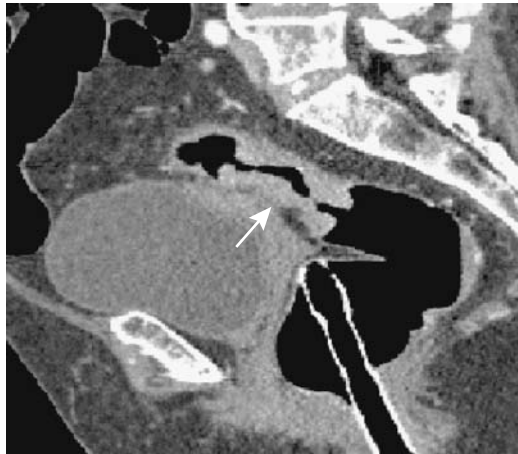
Obstructing carcinoma (arrow). CT colonography can also study the proximal colon. Sagittal images are helpful in surgical planning. (Courtesy of W. Luboldt, M.D., Johann Wolfgang Goethe University, Frankfurt-am-Main.)
